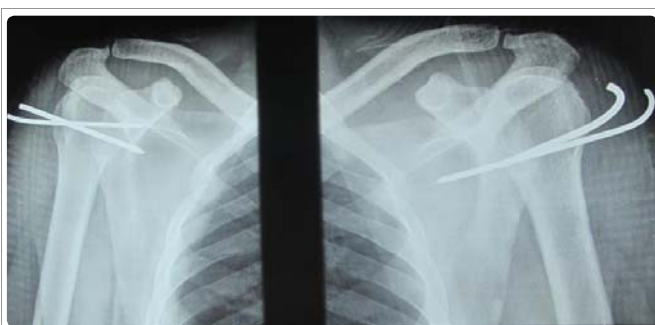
A.Y. 31 years old: the anteroposterior radiographs of the 2 shoulders confirm the anatomical reduction.
